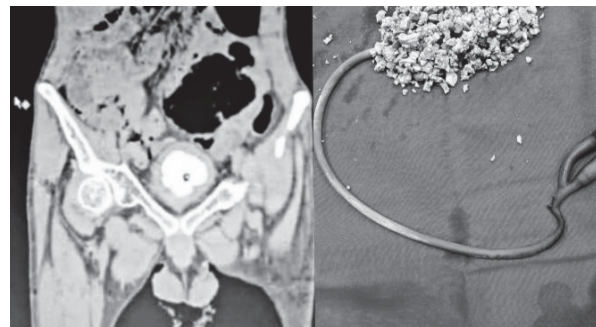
CT shows rounded stone around the tip and balloon of catheter (A); Foley's catheter with fragmented stones around the tip (B).
